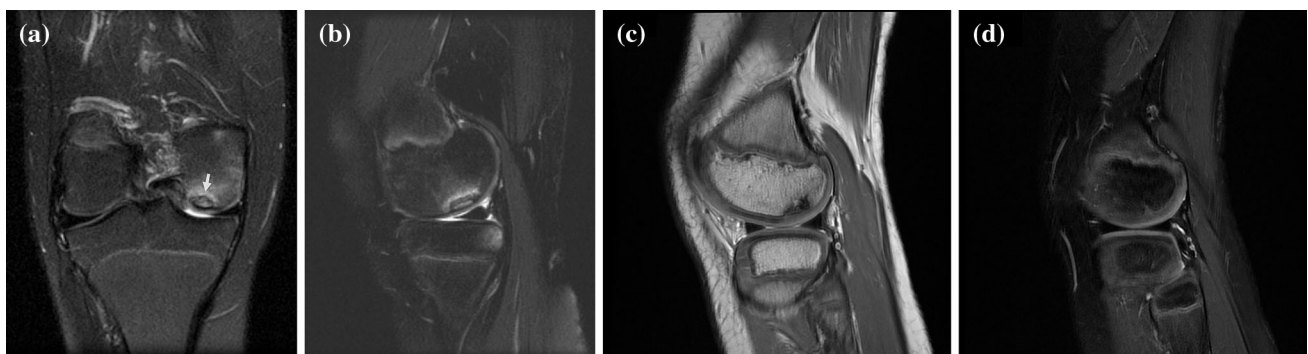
MRI of osteochondritis dissecans in a 13-year-old girl (a, b) versus variation of normal developmental anatomy in a separate patient (c, d)
